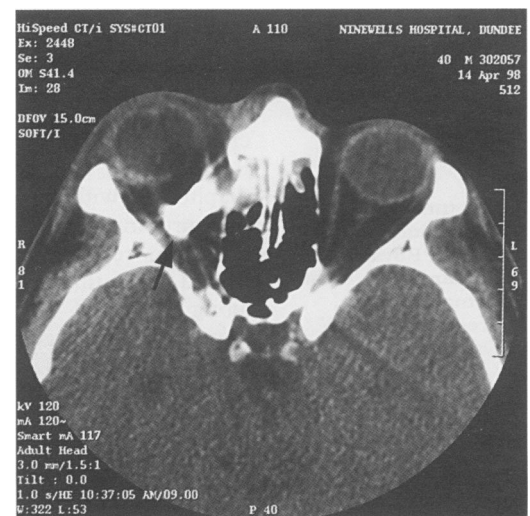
Computed tomography showing a metal foreign body within the right orbit associated with a fracture of the medial wall of the orbit. It is seen lying superior to the optic nerve and lateral rectus, and inferior to medial rectus (arrow). Medial rectus appeared to have been pierced by the foreign body; the globe appeared intact.
